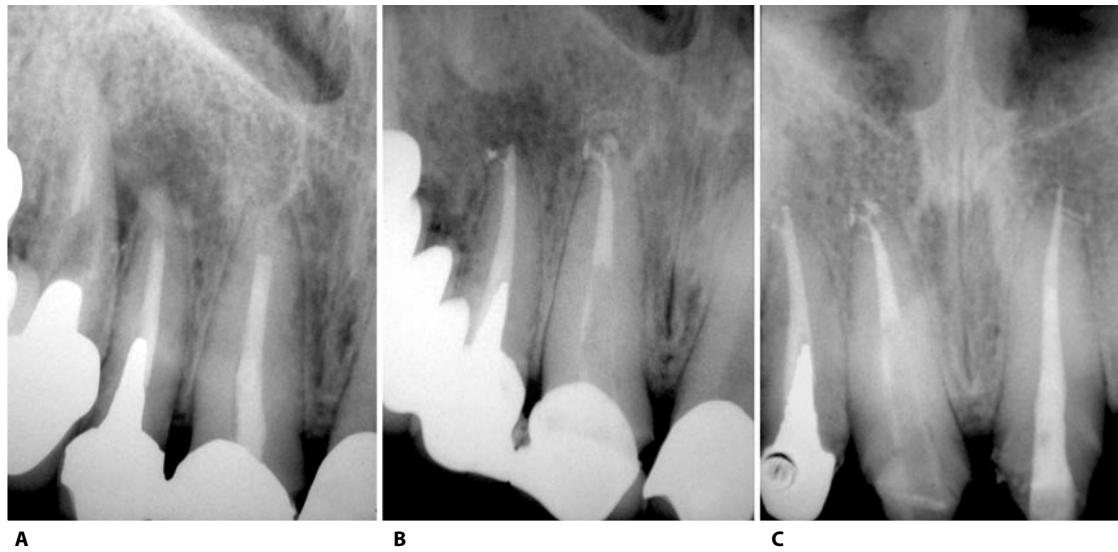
A. Endodontic retreatment of the upper right lateral and central incisors. B. Post-operative radiograph; in the central incisor a carbon fiber post has been inserted. C. One year recall, after retreatment of the upper left central incisor and before cementation of new prosthesis. Note the healing of the periapical lesion of the lateral incisor and the presence of numerous lateral canals in all the treated teeth.
